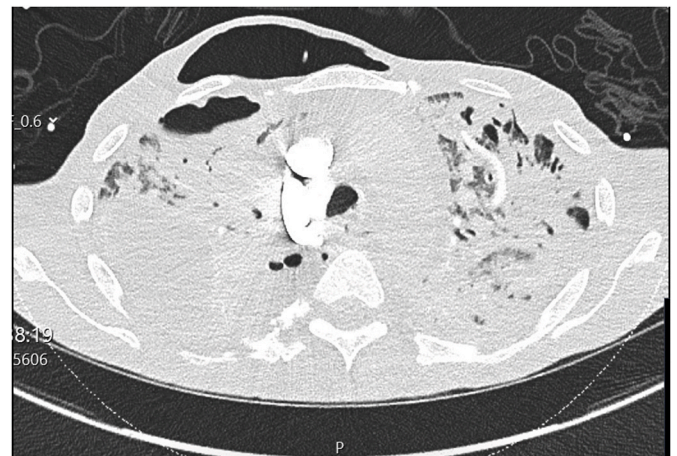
CT scan showing large gas-filled cavity overlying the subcutaneous tissues.
